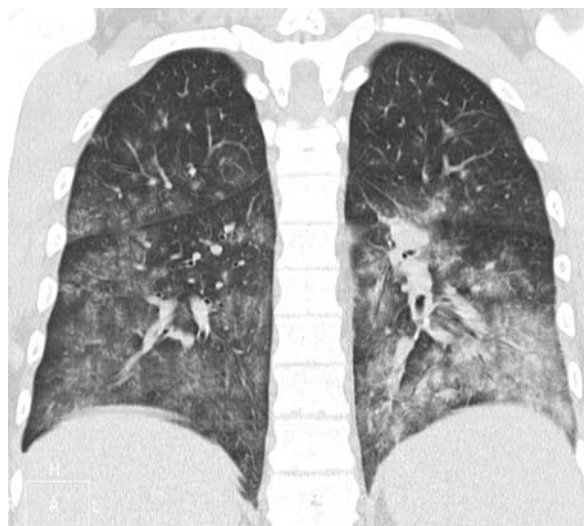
Severe acute H1N1 pneumonia. HRCT of a 48-year-old man with H1N1 pneumonia shows extensive bilateral ground-glass opacities. HRCT indicates high-resolution CT.
